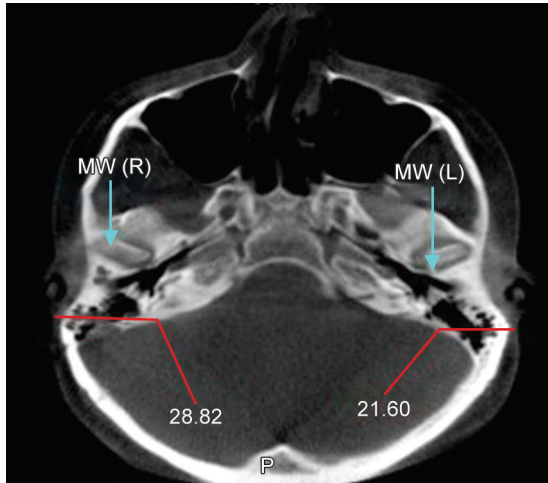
CBCT image: Measurement of mastoid width (MW) of both sites
